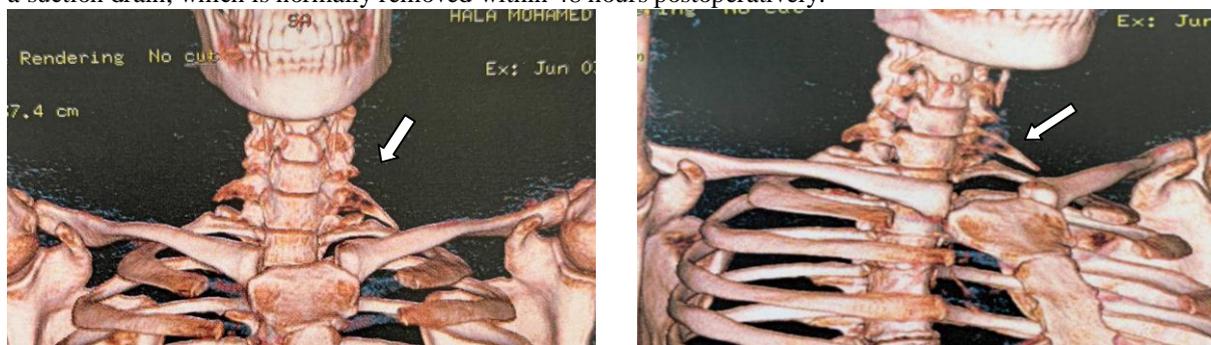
Preoperative three-dimensional computed tomography of a 42-year-old female patient showing left cervical rib; and prominent transverse process of the right side. The left was symptomatic (arrow) and she had severe neck and left upper limb radiculopathy not relieved by analgesics. with marked oedema of the left upper limb.
